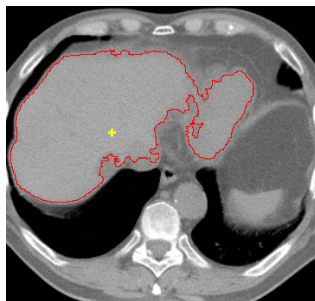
CT liver segmentation using region growing shows boundary leakage. The seed point is marked as a cross.
